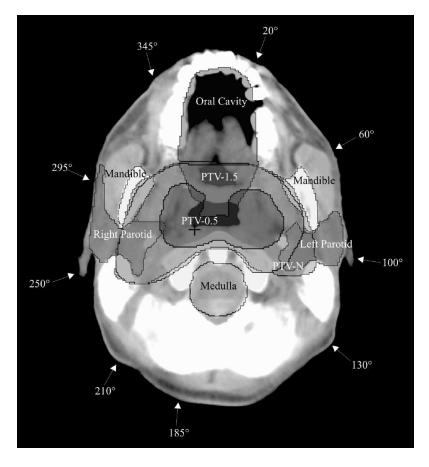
A CT slice of Patient 3 seen from below, with delineated PTV's and OR's. The cross represents the isocenter and the arrows represent the angles for the optimized beam configuration from the first run.
